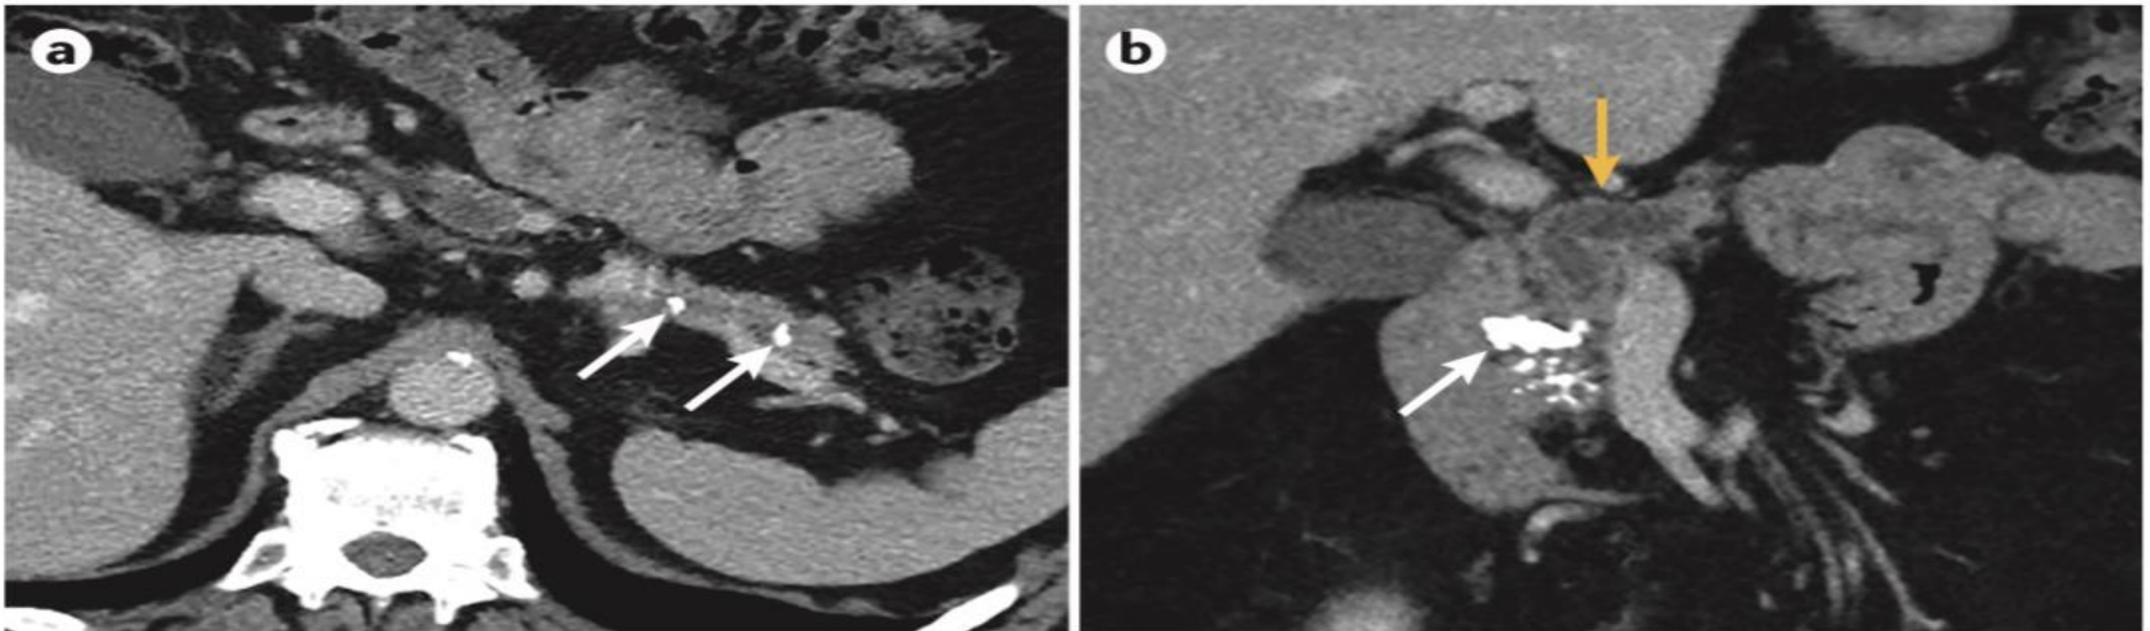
CT imaging in chronic pancreatitis. Post-contrast CT image of severe chronic pancreatitis shows ductal stones (white arrows in part a and part b) within the dilated pancreatic duct (orange arrow; part b).
